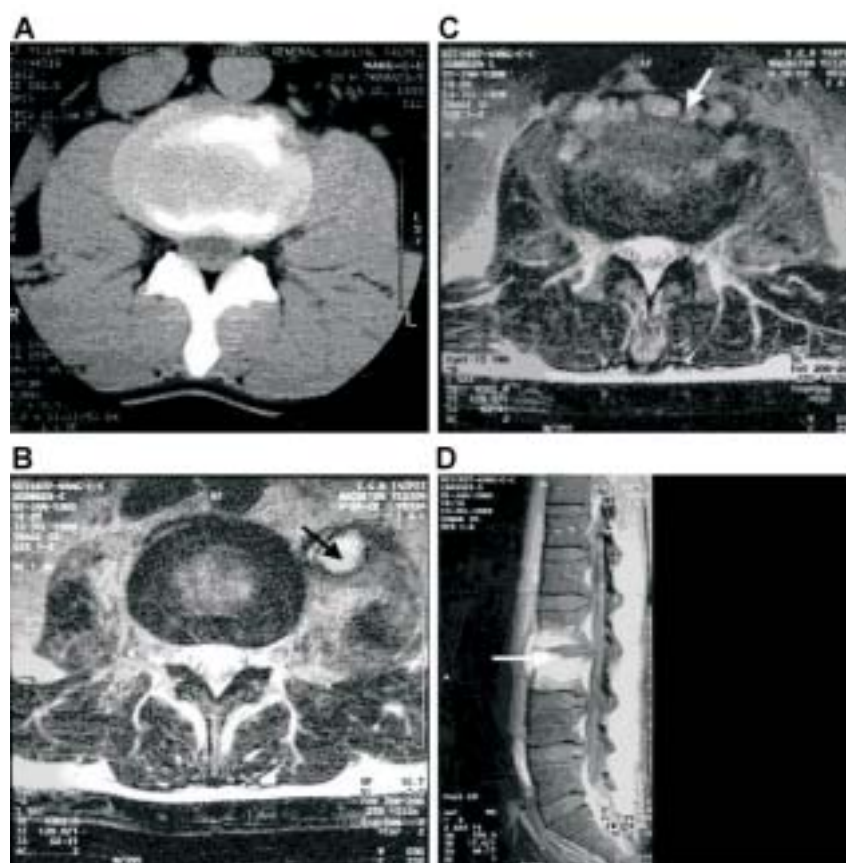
(A) Isodense infective tissue might be merged with disc on the initial unenhanced CT at L2/3. (B) T2-weighted images shows L2-3 disc (arrow) and (C) psoas abscesses (arrow). (D) Sagittal T1-weighted image following contrast administration demonstrates hyperintense vertebral bodies along the L2/L3 segment (arrow).
